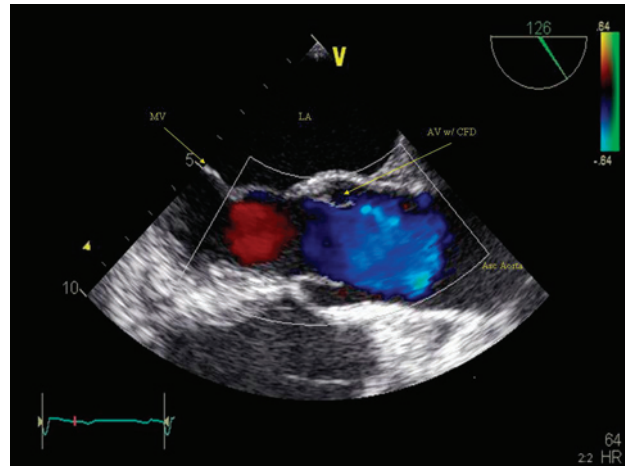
Mid-esophageal aortic valve long-axis with colorflow Doppler.
